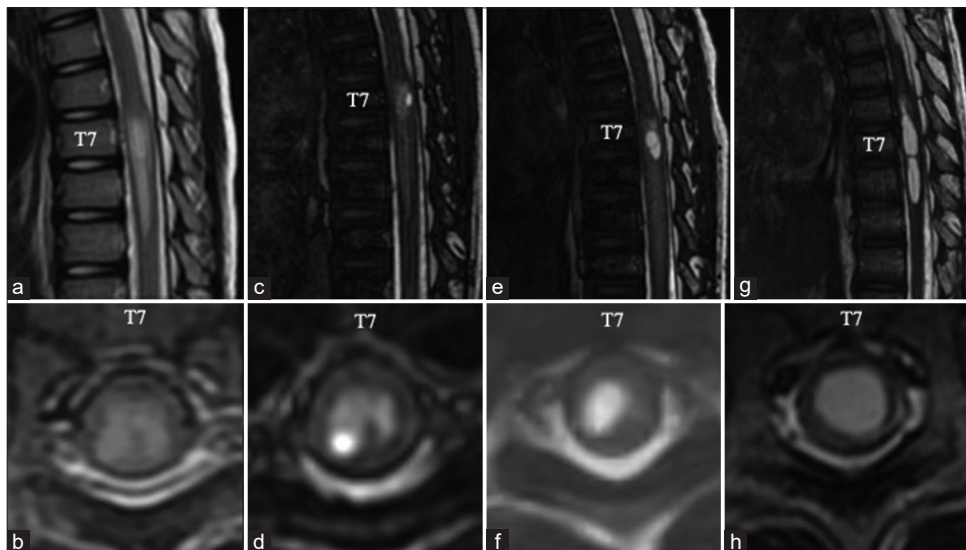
(a) Sagittal T2-weighted magnetic resonance (MR) image at age 5 years showing the newly emerging T2 prolongation at T7-T9. (b) Axial T2-weighted MR image showing the abnormal T2 prolongation confined to the gray matter with no frank cavitation. At this time, the patient was still asymptomatic. (c and d) Six months later, the patient complained of intermittent pain and weakness in his lower limbs. MR image showing syringomyelia cavitation in the right posterior horn at T7. (e and f) Magnetic resonance (MR) image at age 6 years showing that the syrinx was enlarged and expanded throughout the right gray matter. Since retethering was considered the cause of the intermittent lower limb symptoms and the progression of syringomyelia, a revision untethering surgery was performed. After the operation, symptoms were resolved. (g and h) However, on MR imaging 6 months after surgery, the syrinx had enlarged into the entire spinal parenchyma.
